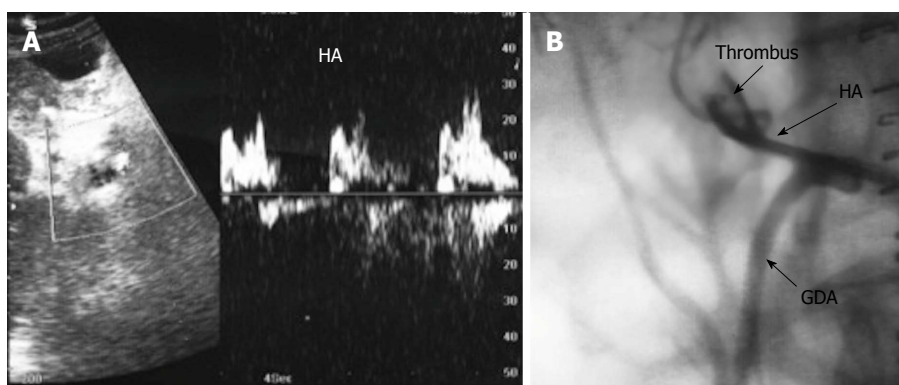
Post-operative hepatic artery impending thrombosis in a patient with stable liver enzymes, 3 d post-living donor liver transplantation. A: Doppler US image, showing abnormal arterial waveform with damped irregular systole, absent and reversed diastolic flow (suspicious of impending thrombosis); B: Arterial angiography performed after 2 h showing acute thrombosis and dilatation of the recipient HA proper. Intra-arterial thrombolysis was performed successfully. HA: Hepatic artery.
